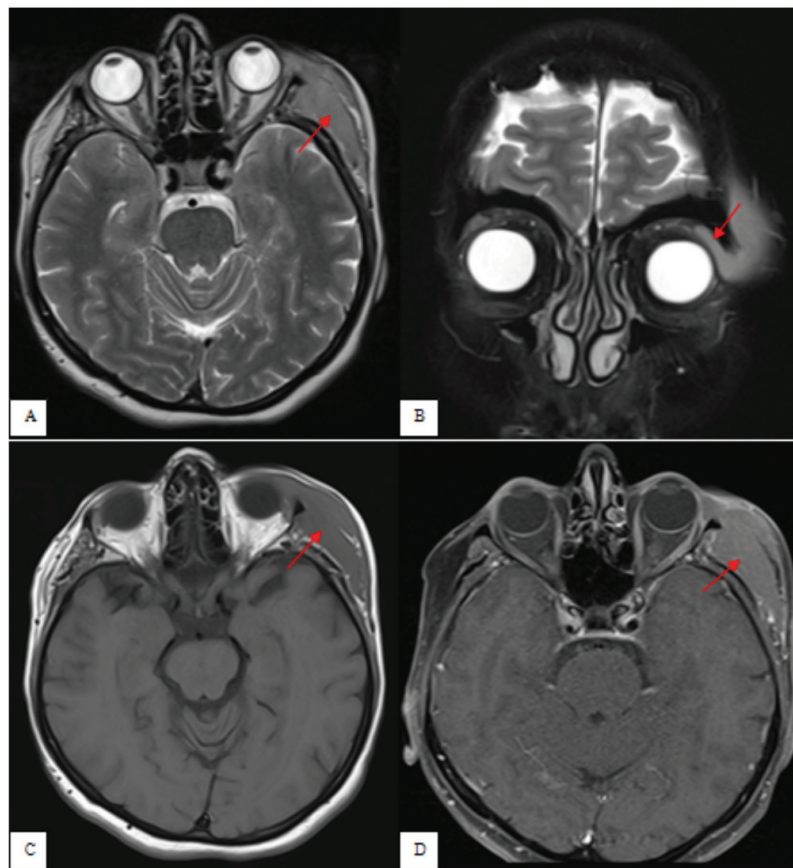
MRI of the brain and the orbit showing the left temporal region mass on axial T2w image (A, arrow). Intraorbital extension of the mass near the lacrimal gland in the left superolateral orbital quadrant is shown on coronal T2w image (B, arrow). The mass is hyperintense to extraocular muscles on T2w images (A, B) and isointense on T1w image (C). On postcontrast T1w image, homogenous moderate enhancement of the mass is seen (D, arrow)
